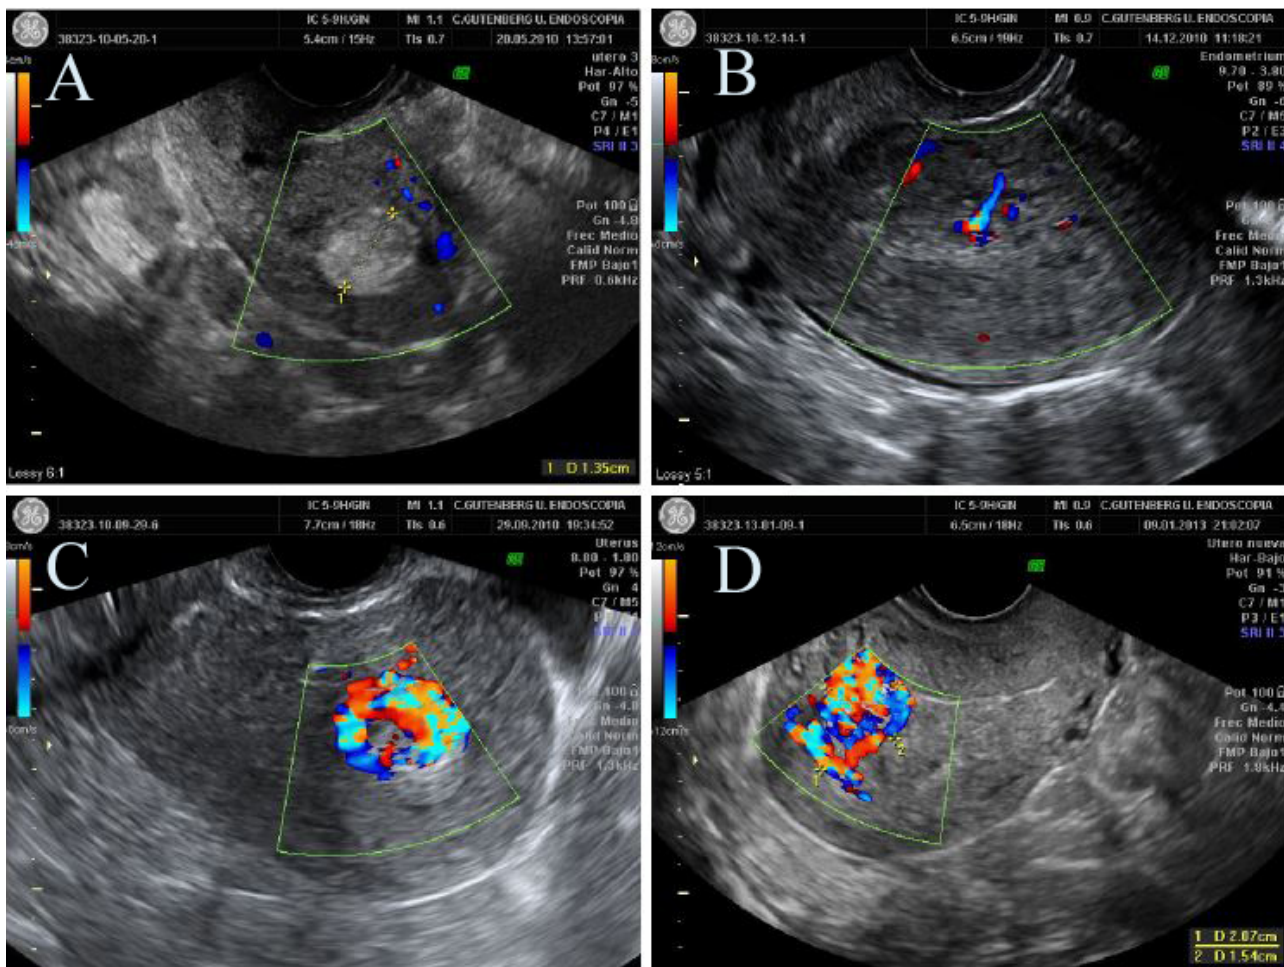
Ultrasonographic patterns of RPOC. Gutenberg Classification. A- Type 0: hyperechogenic avascular mass. B-Type 1: Different echoes with minimal or no vascularisation. C- Type 2: Highly vascularised mass confined to the cavity. D- Type 3: Highly vascularised mass with highly vascularised endometrium (Reproduced with permission from Alonso Pacheco et al., 2019).
